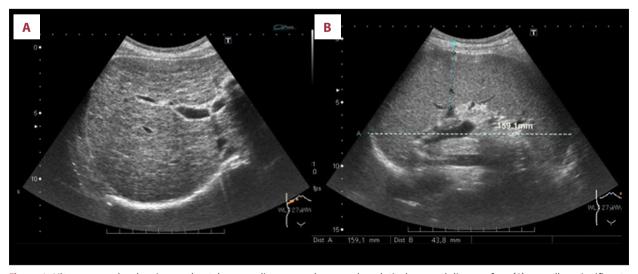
Ultrasonography showing moderately coarse liver parenchyma and a relatively smooth liver surface (A) as well as significant splenomegaly (15.9 cm in length) (B).
